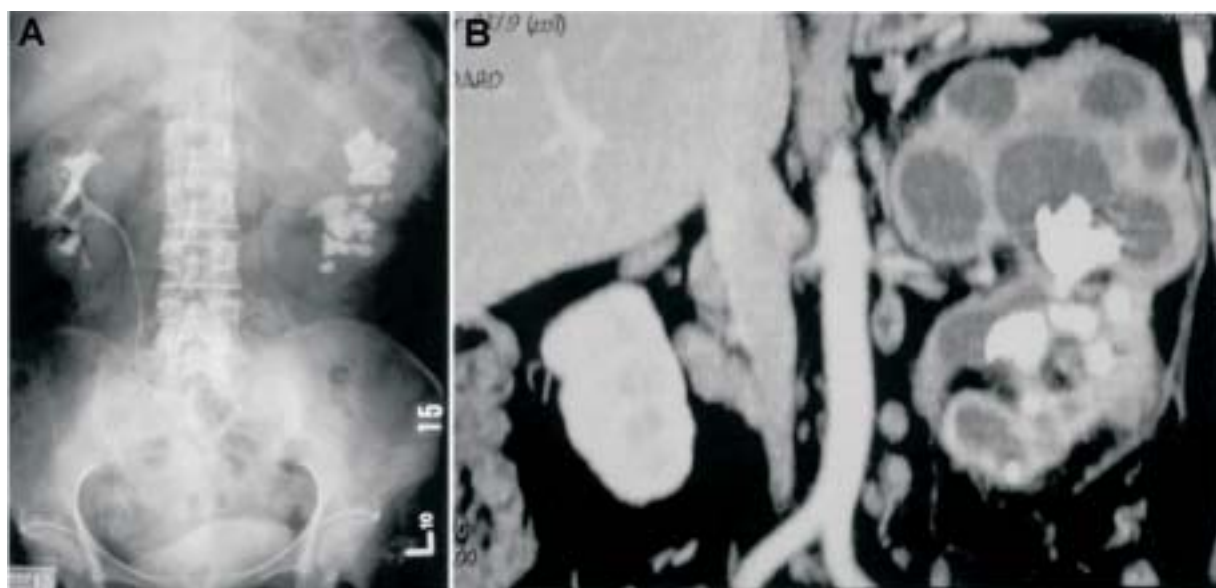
A 56-year-old woman with history of diabetes mellitus, clinically manifested as fever and left flank pain. (A) IVU shows minimal enhancement of left kidney, with suspicious space occupying mass at upper pole. A staghorn stone of the left kidney is also noted. (B) CT urography shows multiple loculated cysts of the upper pole of the left kidney and staghorn stone within the left renal pelvis. Xanthogranulomatous pyelonephritis was diagnosed by CT urography with subsequently surgical confirmation.
